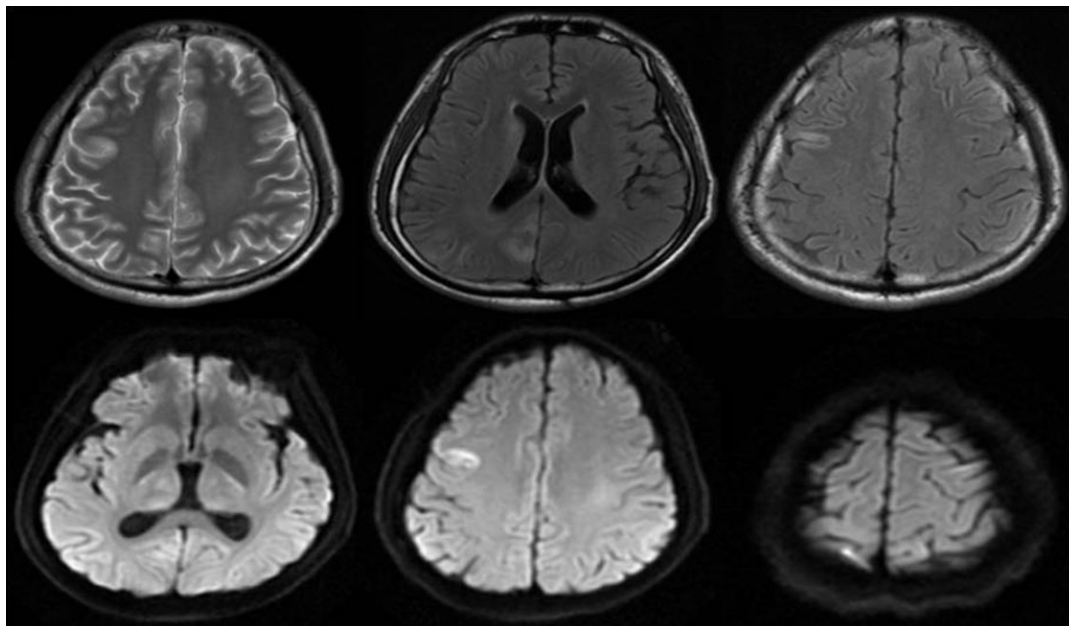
Abnormal signal can be seen in the right frontal lobe, occipital lobe and bilateral dorsal thalamus, caudate nucleus in the brain magnetic resonance imaging, shows high signal on T2WI and a slightly higher signal on Flair, shows high signal diffusion weighted imaging
